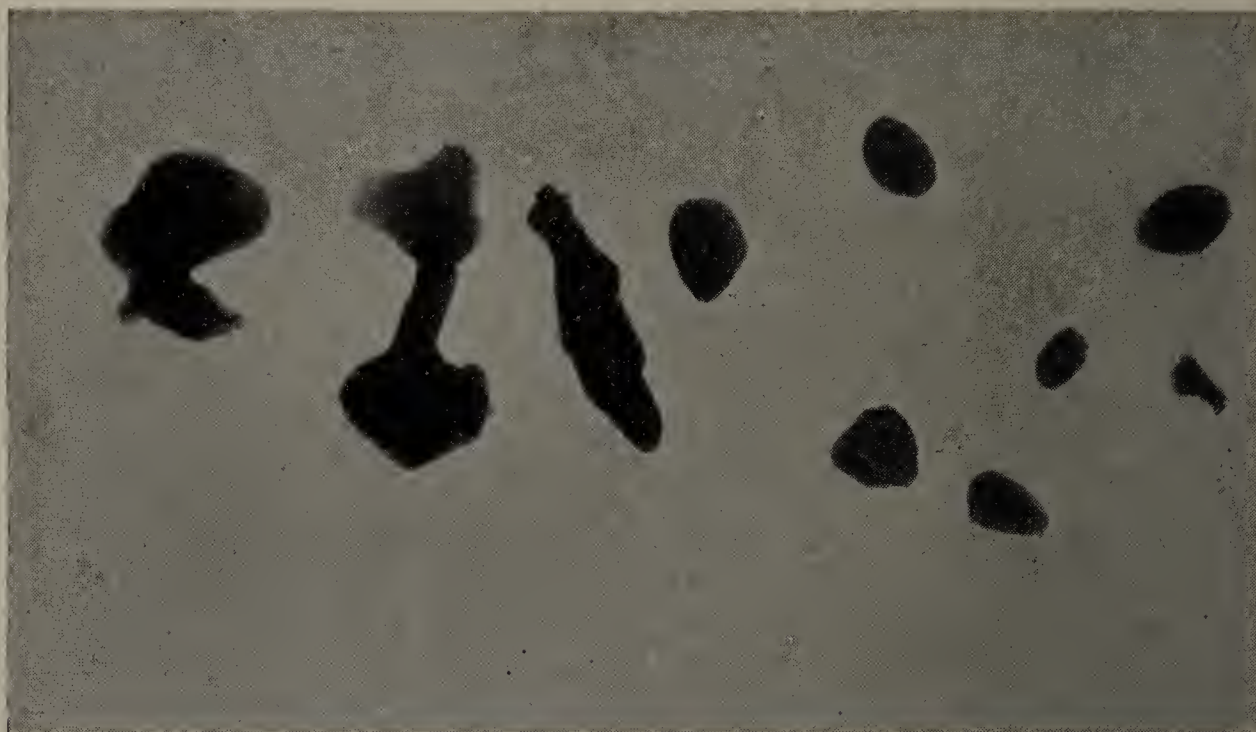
Shows a radiograph of the calculi after they had been removed from the kidney.
